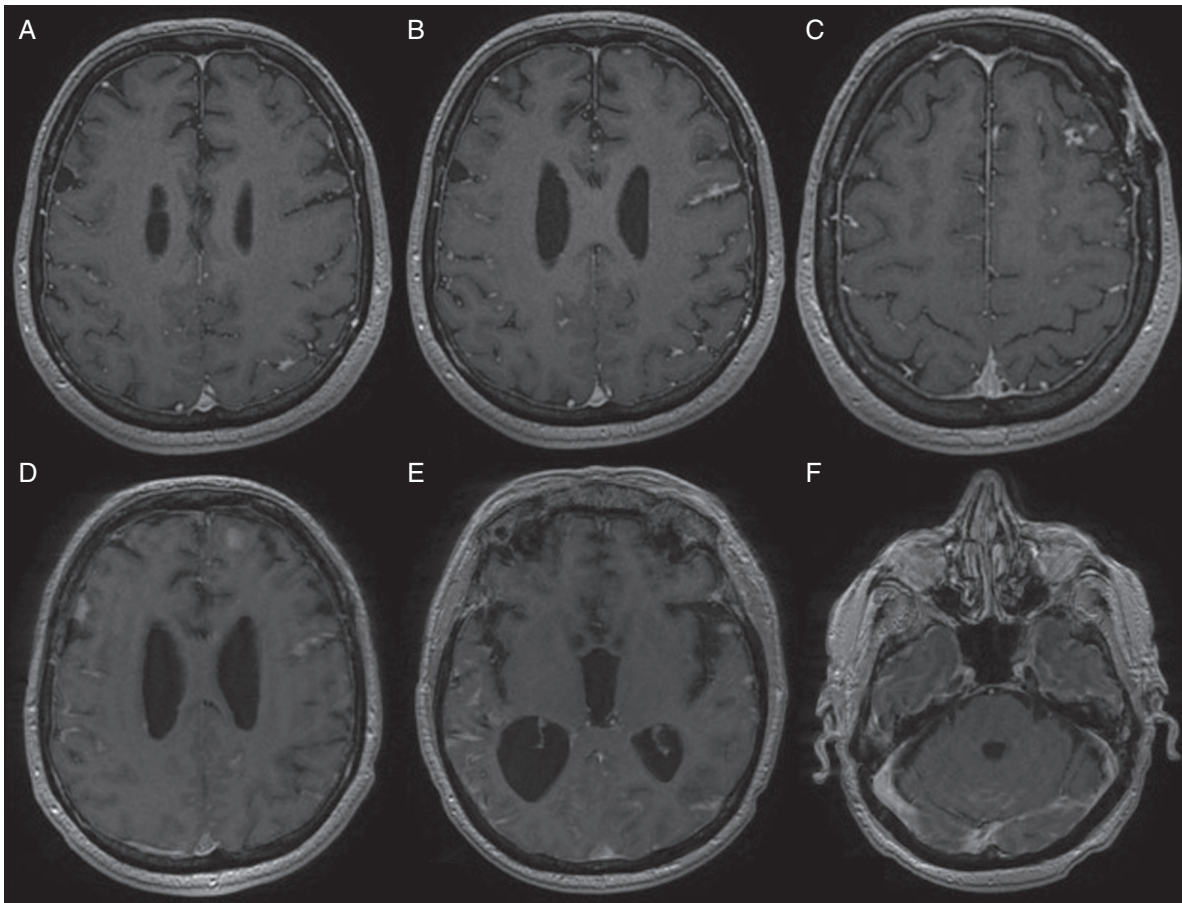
T1 post-contrast MRI brain studies showing recurrence with leptomeningeal disease: (a) left parietal, (b) left frontal, (c) left frontal; rapid progression was seen on follow-up scan, (d-f) multifocal areas of leptomeningeal enhancement.
